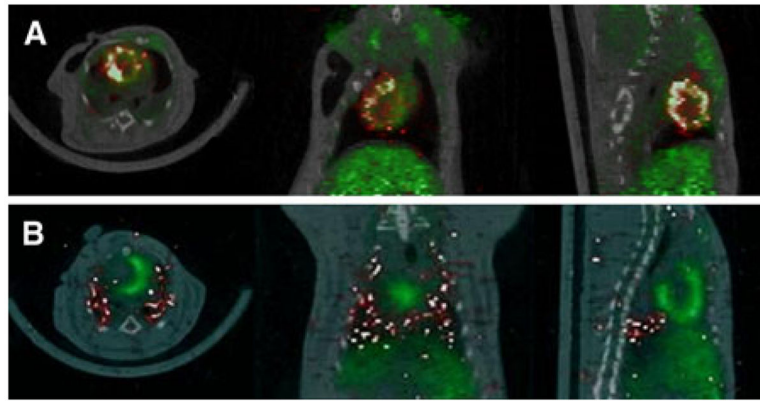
Quantitative in vivo PET results. A In vivo PET/CT imaging following intracoronary rCDC injection. *Yellow arrows* indicate ^{18}F FDG-labeled rCDCs; myocardium (*green*) is delineated by ^{13}N H_3 . B In vivo PET/CT imaging following intravenous rCDC injection. *Yellow arrows* indicate ^{18}F FDG-labeled CDCs; myocardium (*green*) is delineated by ^{13}N H_3 .
